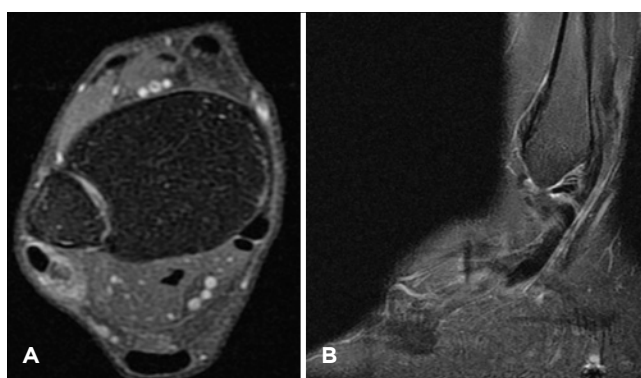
A-B) MRI first patient in an axial and a sagittal cut showing the lesion on the peroneals tendons.
